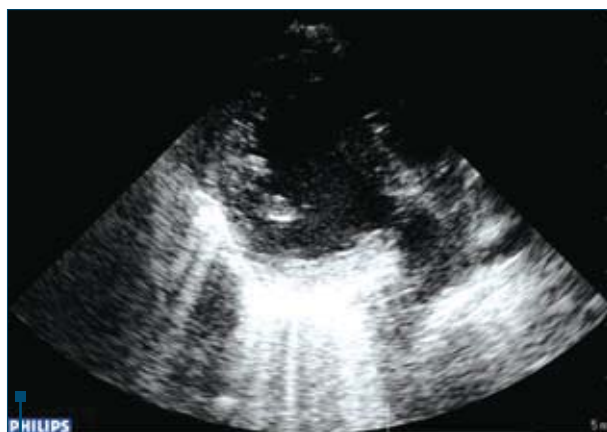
Transposition of great vessels with interventricular septal defect in the parasternal incidence - long axis, in new born
